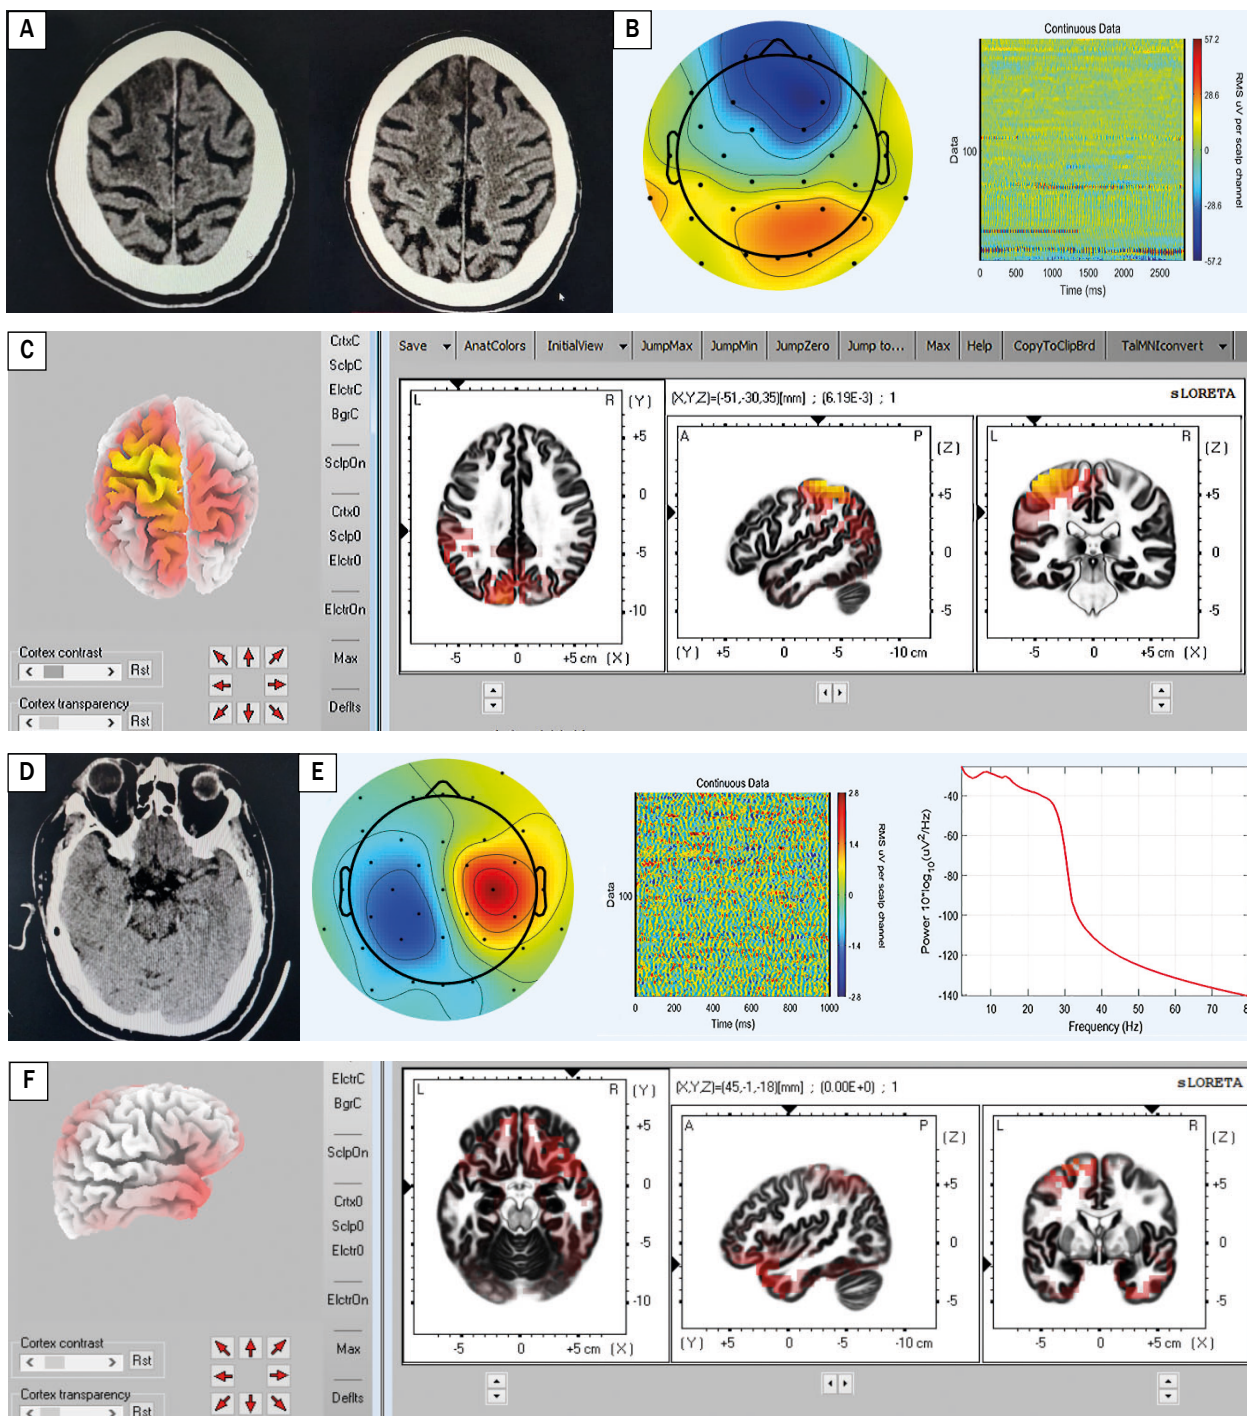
A. Axial CT reveals acute hypodensity in right anterior cerebral artery; B. Independent component analysis in MATLAB-EEGLAB for Patient 1; C. sLORETA algorithm for independent component chosen for Patient 1; D. Axial CT reveals acute hyperdense thrombus in M2 segment of left middle cerebral artery; E. Independent component analysis in MATLAB-EEGLAB for Patient 2; F. sLORETA algorithm for independent component chosen for Patient 2. CT – computed tomography; sLORETA – standardised low resolution electromagnetic tomography software
